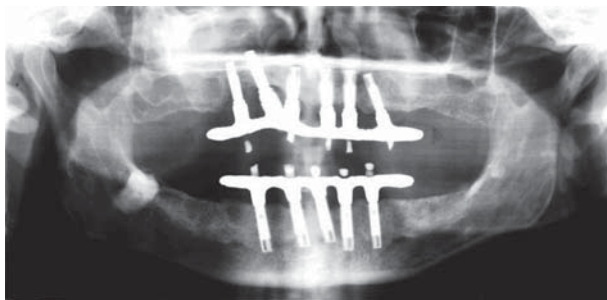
The same patient as in Figure 1. Panoramic radiograph after 5 years of function.
